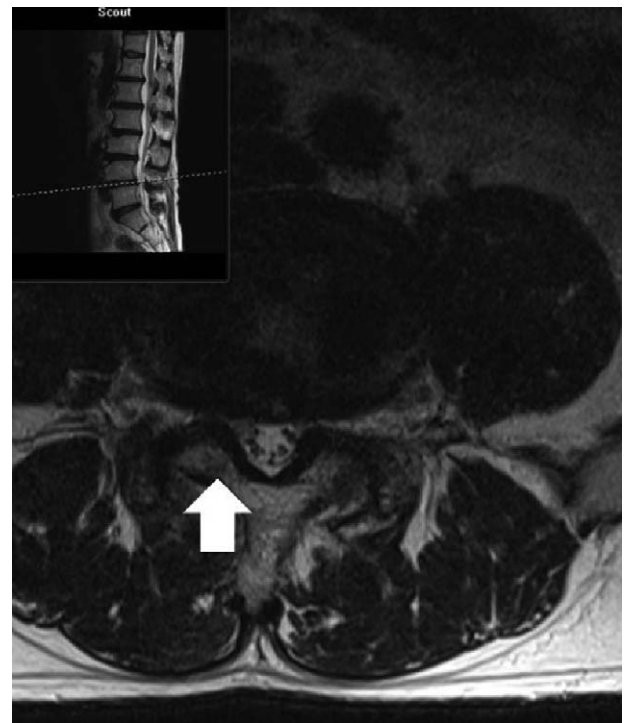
Lumbar magnetic resonance imaging shows right-sided recess stenosis at L4-5 level (arrow).
